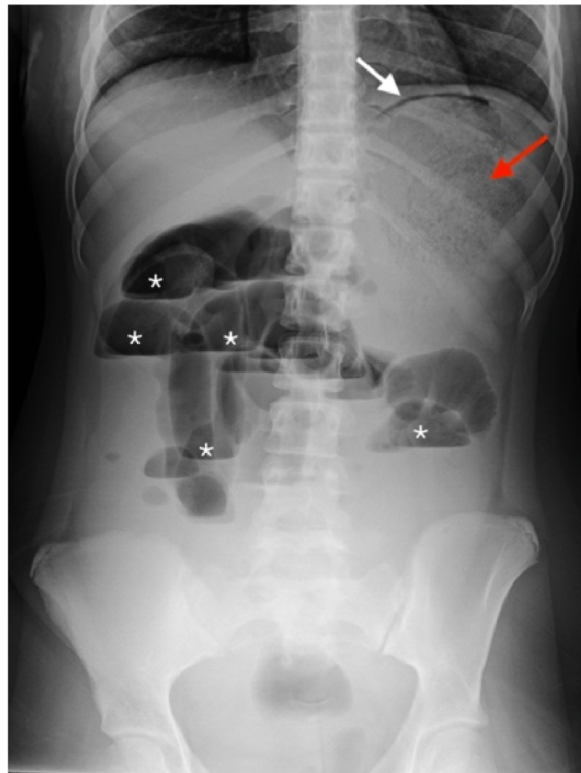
Plain abdominal X-ray demonstrating multiple air-fluid levels (asterisks), stomach filled with ingested material (red arrow), doubt of free air layer (white arrow).
